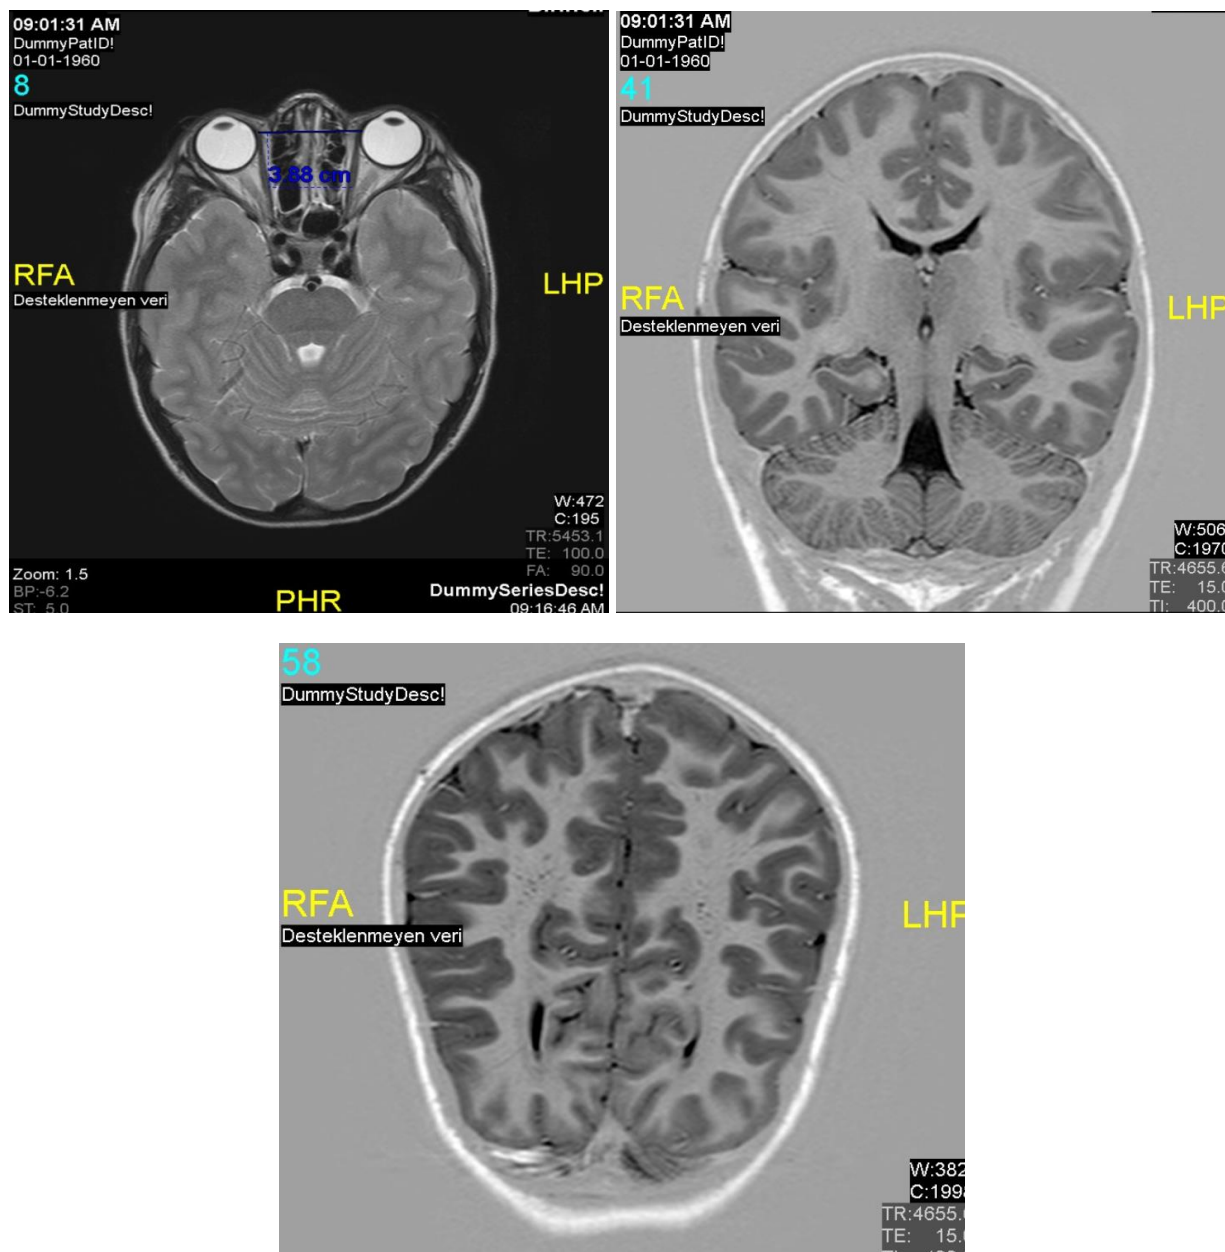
Shows the patient's MRI. She has macrocephaly, hypertelorism, polymicrogyria
